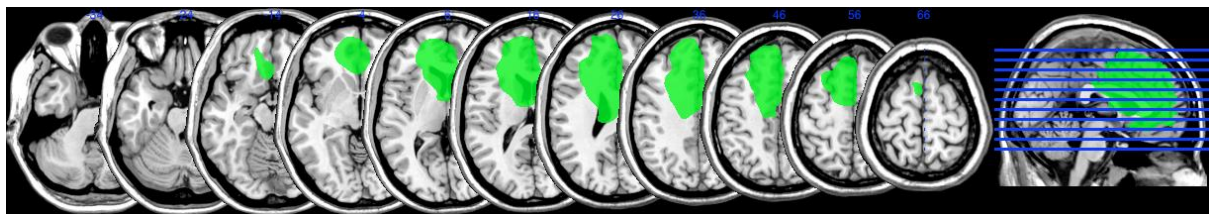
MRI scan of patient TD
